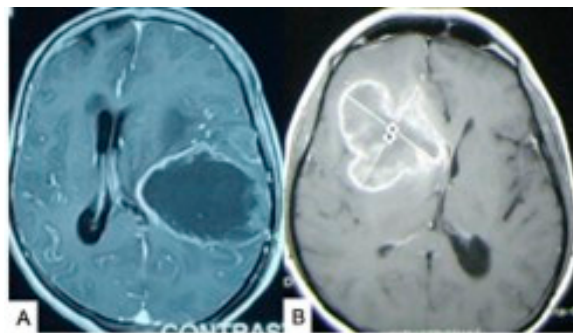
Glioblastomas are typically irregular, peripherally enhancing tumours with central necrosis and mass effect. Contrast MRI axial view: (A) parietal GBM and (B) frontal GBM. Source: Figure by authors.
